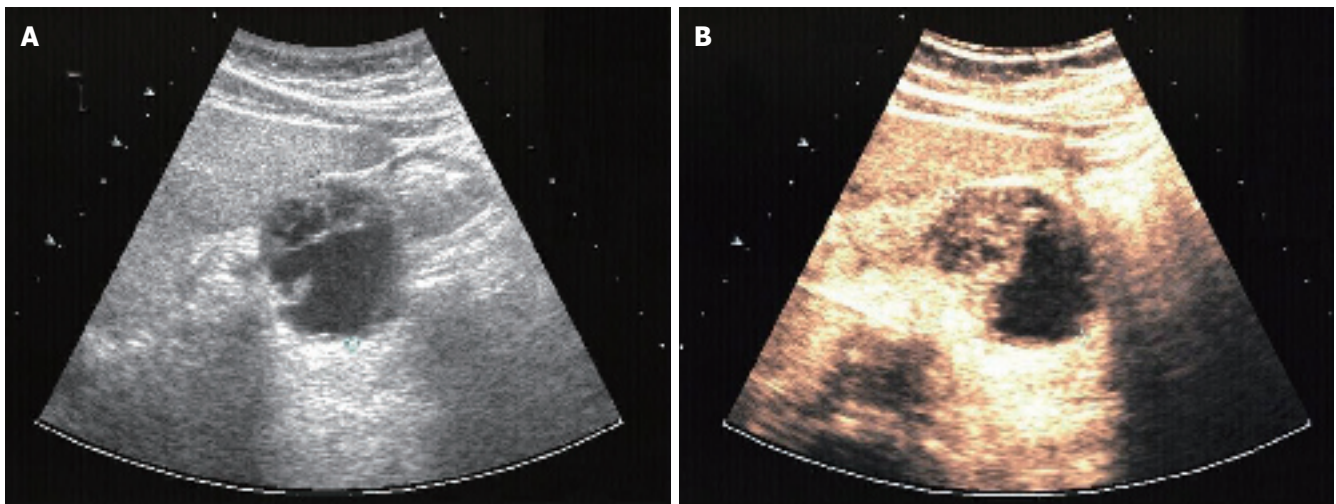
Patient 2: osteoclast-like giant cell tumor of the pancreas. A: B-mode (HDI 5000, Philips) and B: contrast sonography (Sonovue®, low MI/CPS, Acuson Sequoia 512).
